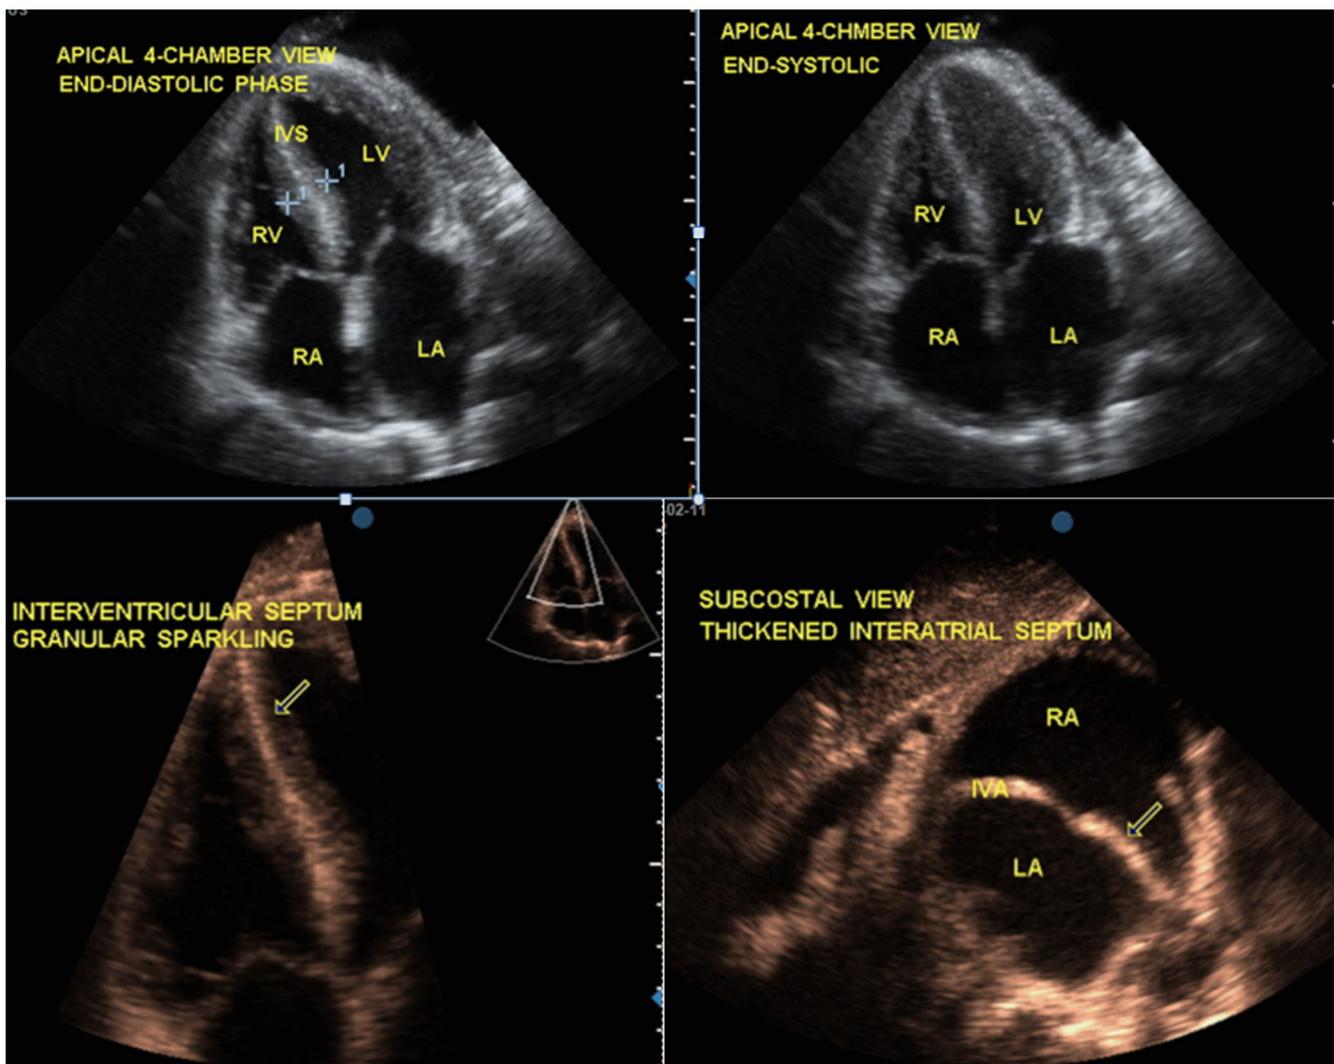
Echocardiograms showing biatrial dilatation, thick ventricular walls and interatrial septum, increased myocardial echogenicity ('granular sparkling'), small pericardium effusion. Note that ventricular chambers are not dilated.
